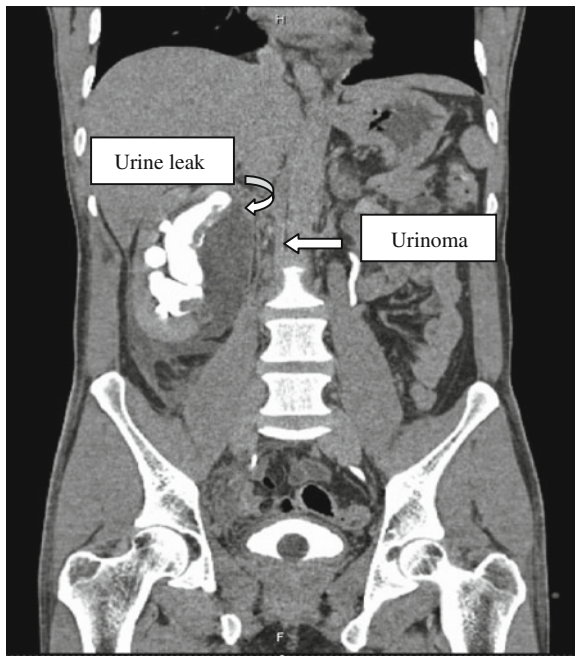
CT urogram demonstrating small leak at the right superior renal pelvis closure site
